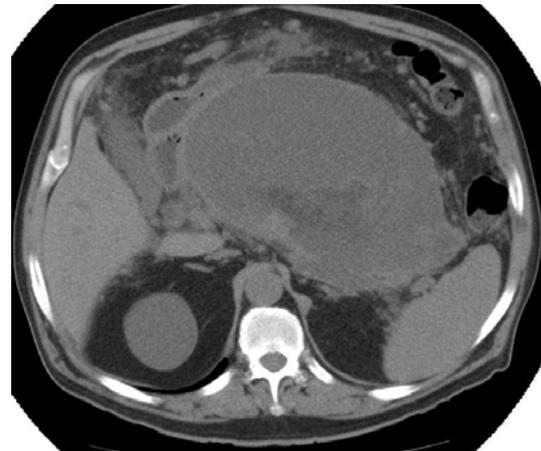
CT: acute necrotic collection
